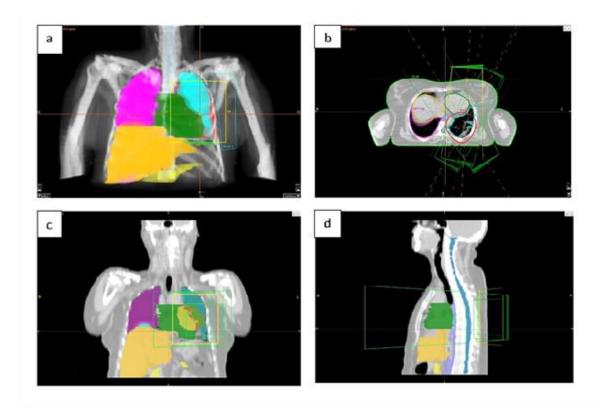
Sample images of 3DCRT treatment plans for one lung cancer patient: digital reconstructed radiograph (DRR) (a), axial (b), coronal (c), and sagittal (d) views
